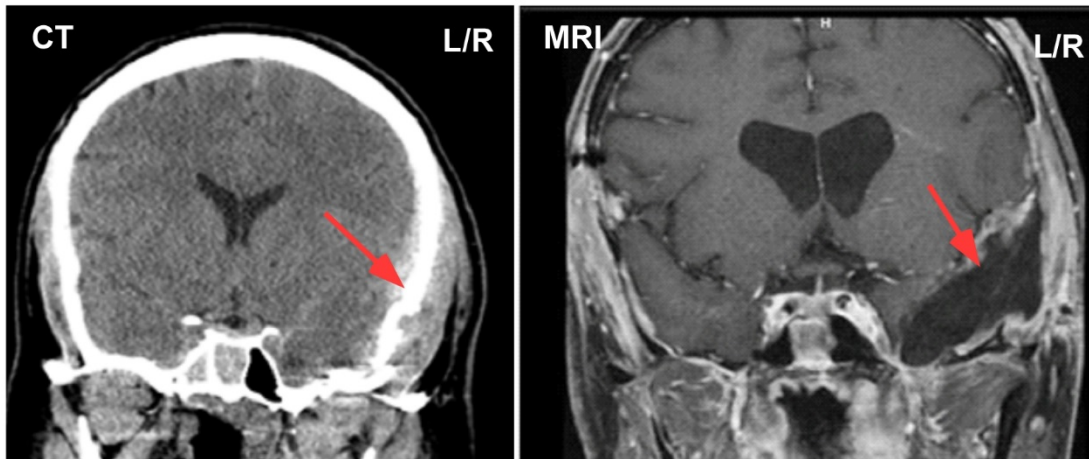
Initial neuroimaging of TB. Day of trauma CT scan (left image). The depressed skull fracture can be seen in the lower right quadrant of the CT scan. Six weeks posttrauma MRI (right image). The dark spot in the bottom left quadrant of the MRI is indicative of a partially removed left temporal lobe (image orientation is left to right, L/R).
